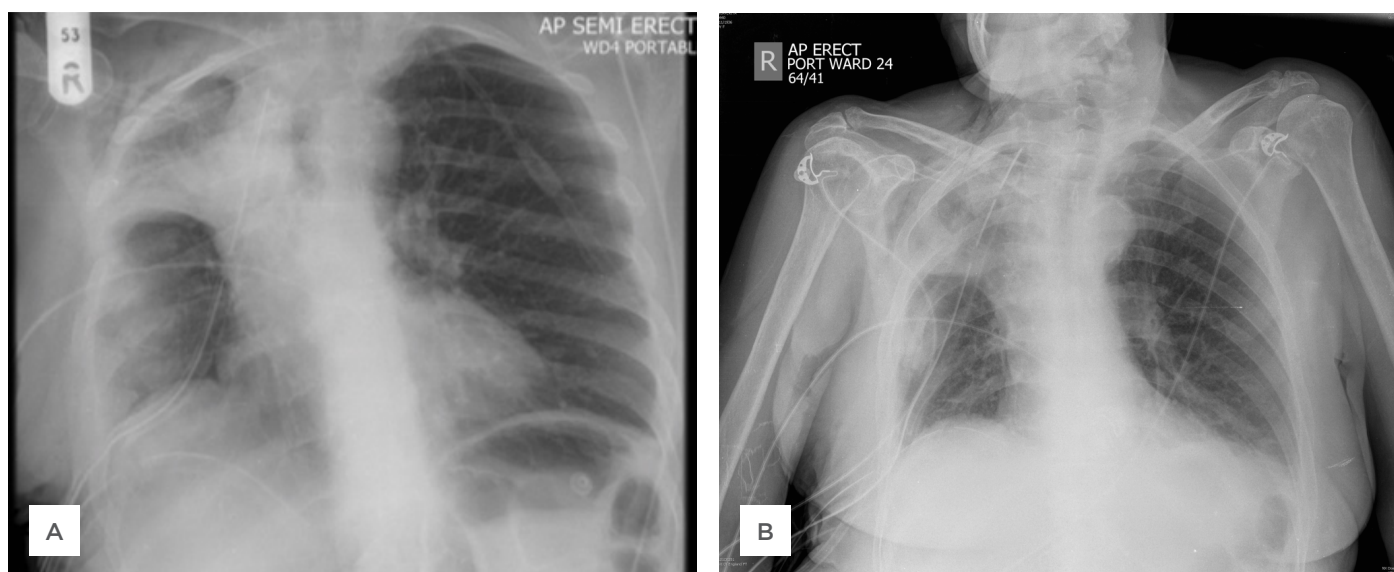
Chest X-ray changes before and after treatment with positive expiratory pressure (PEP) therapy in a patient with respiratory failure following right upper lobectomy surgery. A) Before PEP therapy. B) Increased lung volume and improvement of basal atelectasis after PEP therapy.
